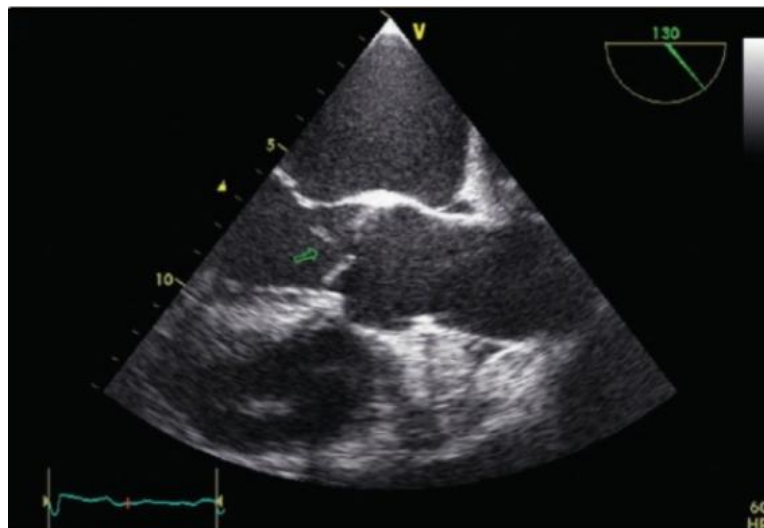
Transesophageal echocardiography, long axis section: Echogenic mobile vegetation of the aortic valve on the ventricular side of the posterior cusp (length 9mm, thickness 3mm) [5]
